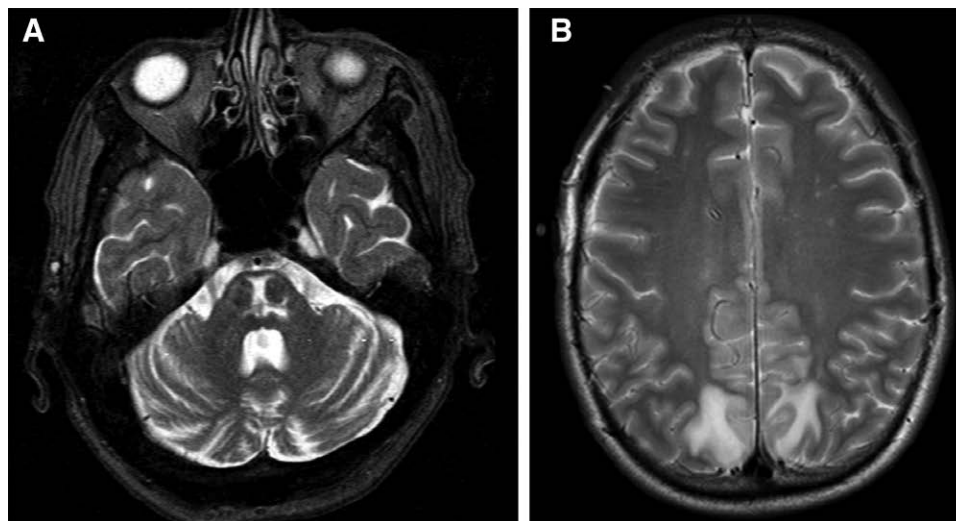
(A) Magnetic resonance imaging of a patient who presented with progressive mental status decline, tremor, and hyponatremia between postoperative day 3 and 8 after orthotopic liver transplantation. The findings reveal patchy foci of T2 hyperintensity with associated restricted diffusion in the central and peripheral pons and are consistent with central pontine myelinolysis. (B) Magnetic resonance imaging of a patient who underwent orthotopic liver transplantation for acute liver failure and developed seizures after commencement of immunosuppression. The seizures were refractory to conventional treatment and alteration of immunosuppressive medications. T2 weighted images acquired during this period reveal symmetrical hyperintensity in the parietal-occipital cortices bilaterally, which is consistent with posterior reversible encephalopathy syndrome.
